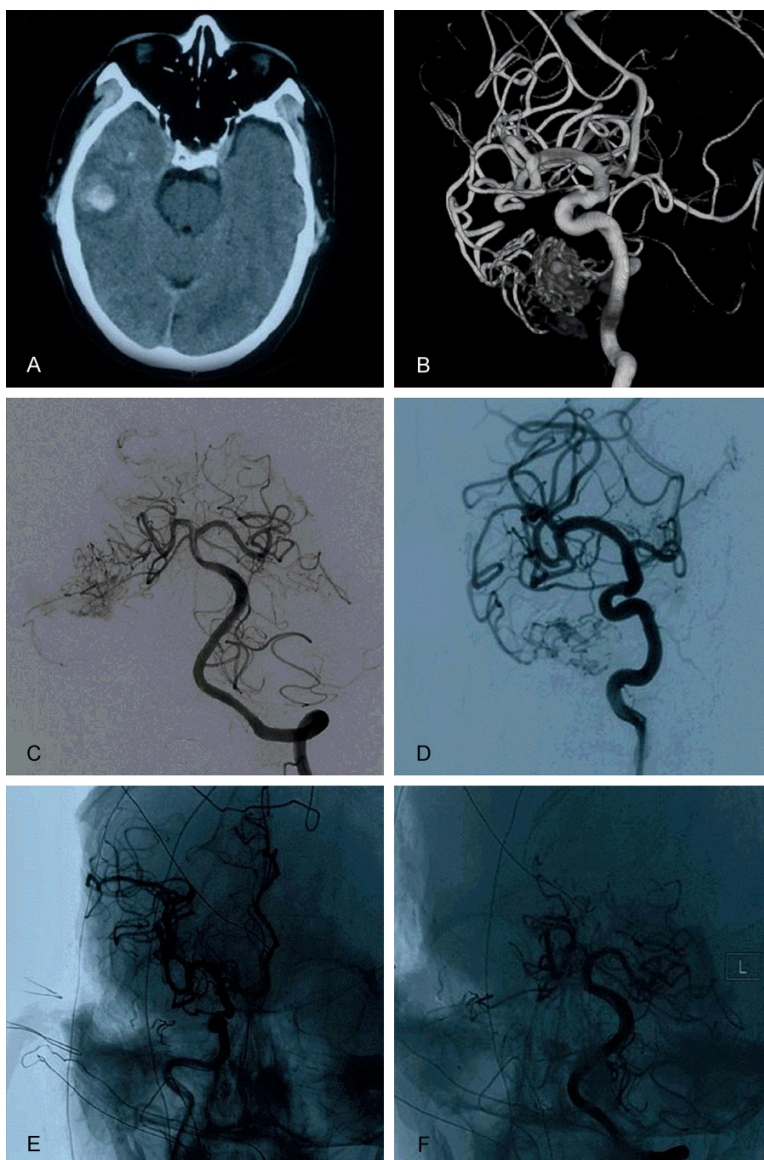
Images of the patient in case 7. A: Head CT shows the hematoma in the right temporal lobe; B: 3D-DSA of the right internal carotid artery shows the AVM in the right temporal lobe, which is fed by the inferior terminal of the MCA; C: Vertebral artery angiography shows that the distal branch of the right PCA is also involved in the blood supply; D: The AVM was partially embolized through the blood supply branch of the MCA; E, F: DSA immediately after the operation shows total resection of the AVM.
